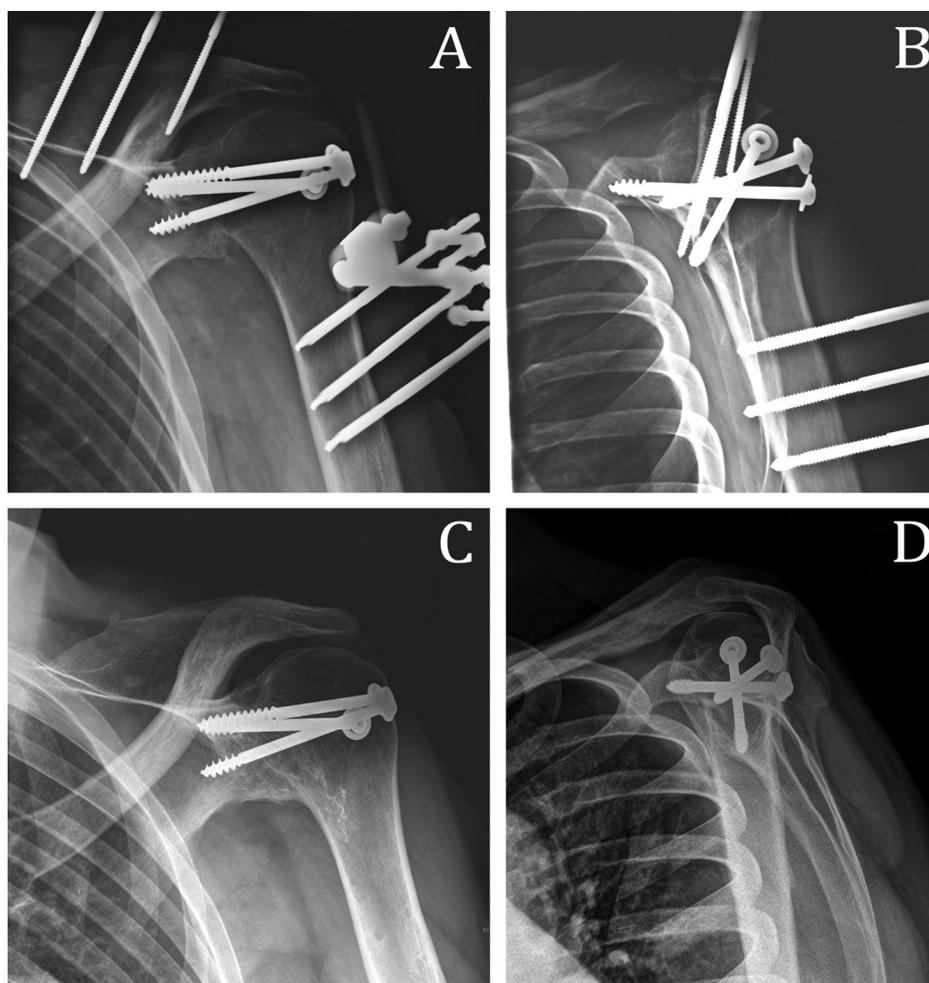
Shoulder arthrodesis by humero-scapular compression-screw fixation combined with external fixation (Hoffmann®, Stryker, Kalamazoo, MI, USA). A and B. Antero-posterior and lateral radiographs 2 months after surgery. C and D. Antero-posterior and lateral radiographs at last follow-up 74 months after surgery.
